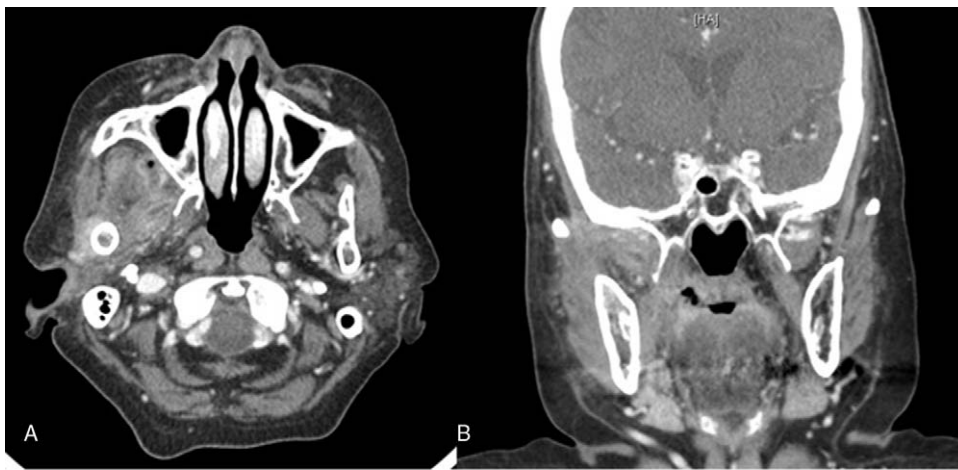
Computed tomography shows remission of abscess in the right pterygomandibular space after drainage. (A) Axial view. (B) Coronal view.
